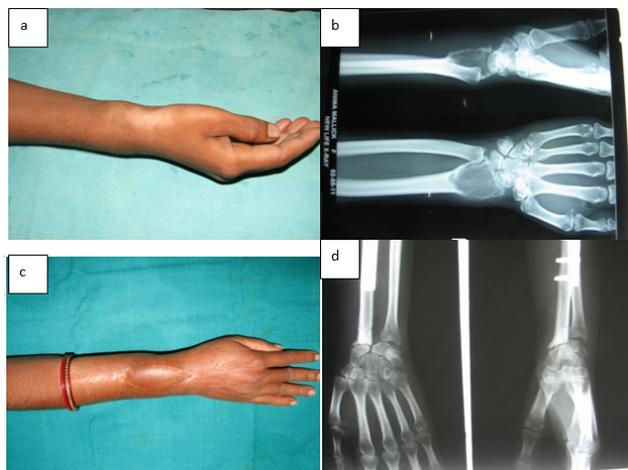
a: Clinical photographs of bony swelling of the distal end of the forearm right side; b: Preoperative X-ray pictures showing giant cell tumor distal end of radius; c: 1 year follow up clinical photograph of right forearm and hand with well settled skin paddle of vascularised free osteo-cutaneous fibula and recipient vessels are radial artery and accompanying vessel and cephalic vein; d: Post operative X-ray picture showing reshaped distal end of the reconstructed radius.
